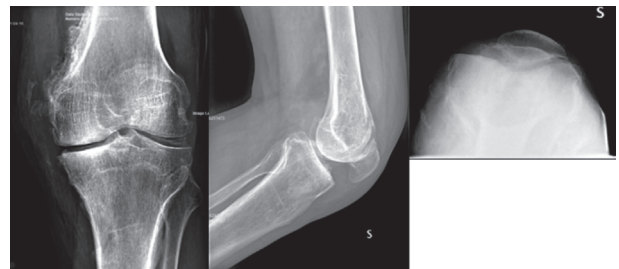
Preoperative radiographs of the left knee showing medial knee OA after Kinespring system explant
